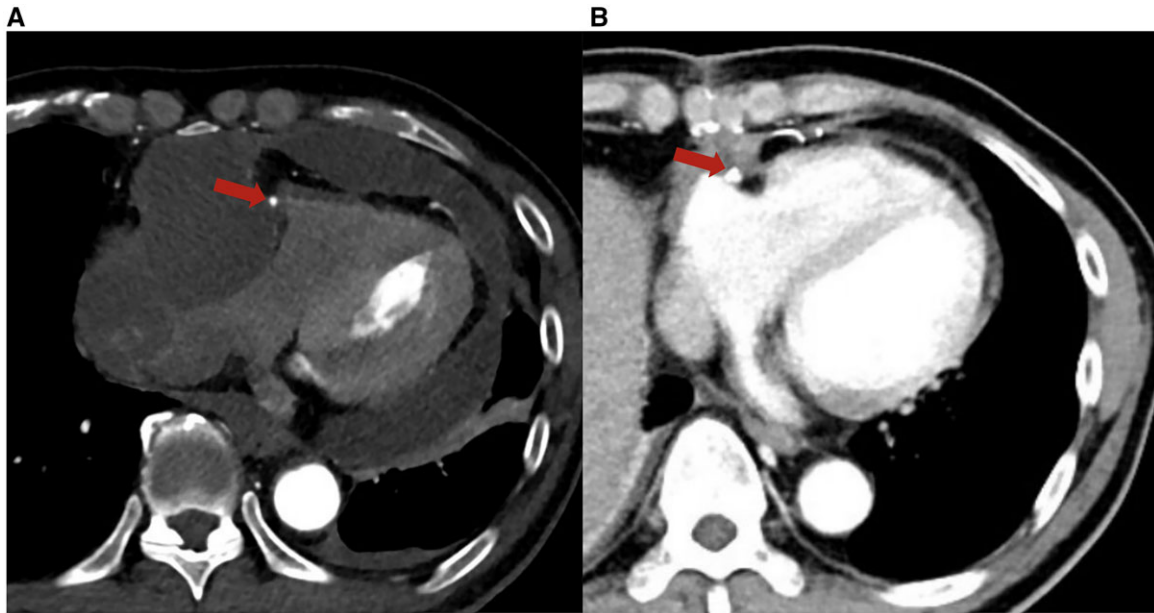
Computed tomography angiography before and after surgery. (A) Preoperatively, the right coronary artery (red arrow) was invaded by the tumour. (B) Postoperatively, the saphenous vein graft (red arrow) was seen passing through the right atrium.
